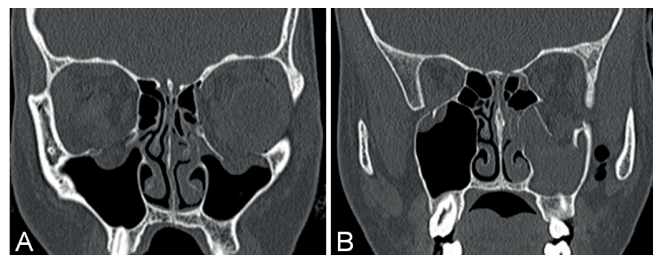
Initial CT examination (A) Bilateral fracture of orbital floor (B) Presence of air in the left pterygopalatine fossa (right).
